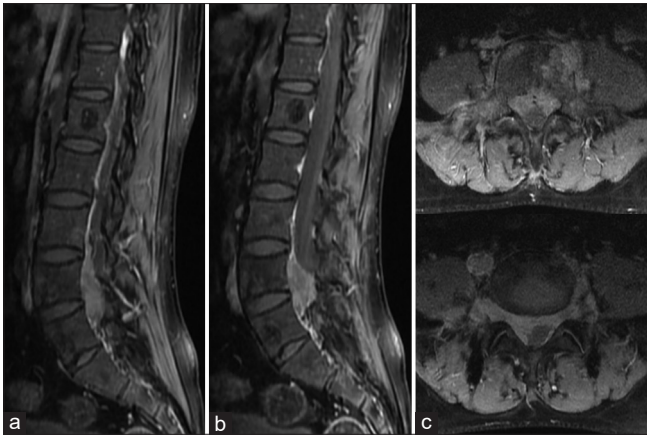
(a-c) Contrast magnetic resonance imaging showing homogenous enhancement of the lesion in L4 body with extension into the spinal canal, pre vertebral and paravertebral region
